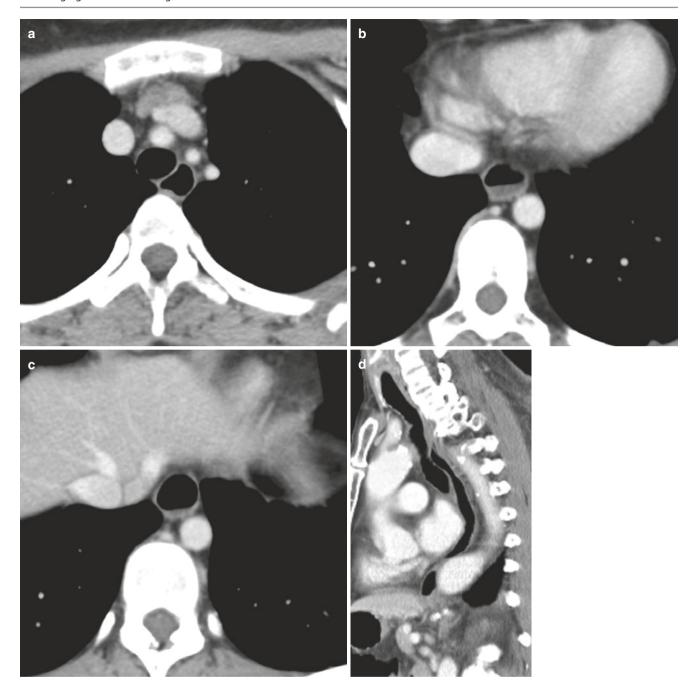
Axial CT images (a-c) showing signs of esophageal dysmotility (dilated esophagus and air-fluid level). (d) Sagittal CT image in another patient shows air in the almost entire course of the esophagus
